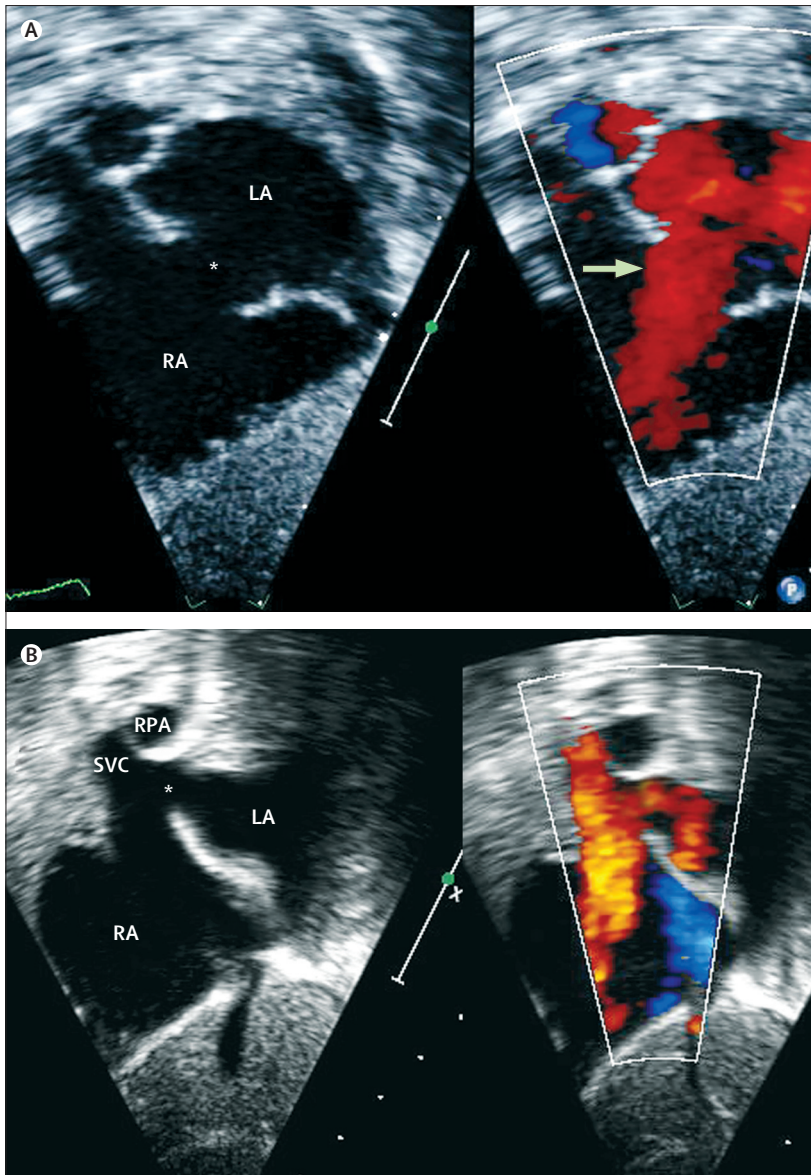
Echocardiographic imaging of atrial defects
